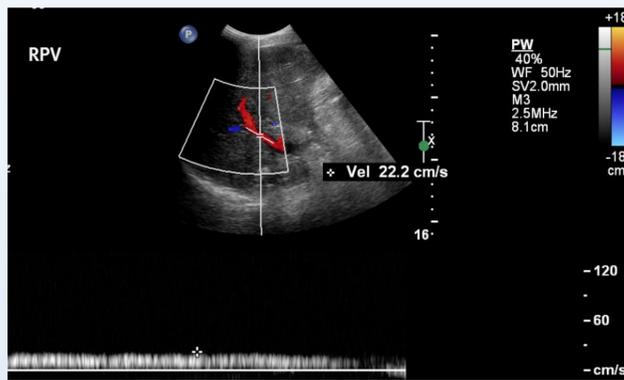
Spectral Doppler of the RPV showing hepato-petal flow
